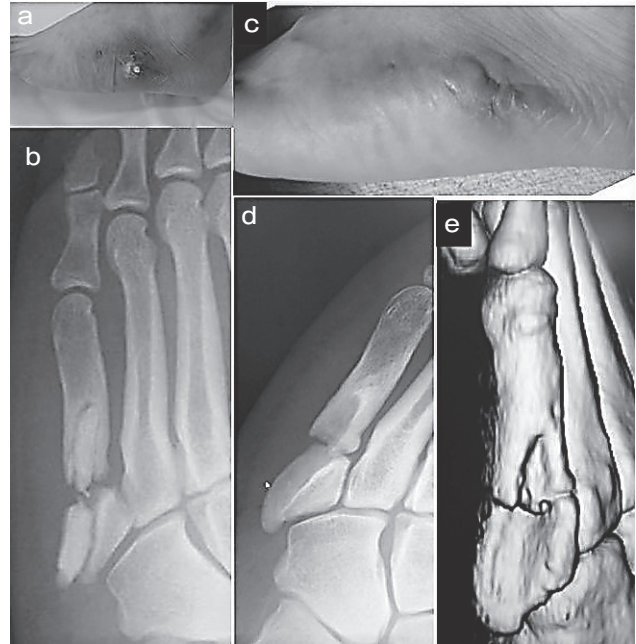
photograph of left foot (a), A-P (a) and oblique (b) of foot X-ray, The bone graft became exposed; photograph of left foot (c) oblique (d) of X-ray and CT of foot (e), The bone graft had to be removed 5 years postoperatively.
